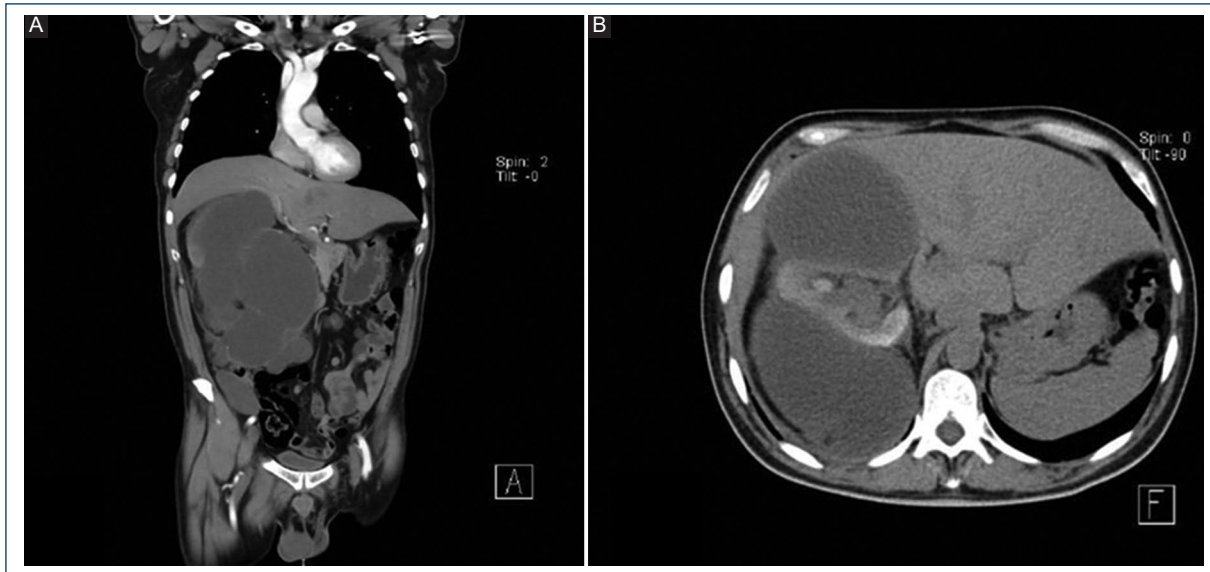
The computed tomography scan reveals a well-defined mass in the right retroperitoneum with a cystic, lobulated, and heterogeneous appearance, likely with mucinous features typical of neoplasms with mass effect. A: axial view; B: coronal view.
